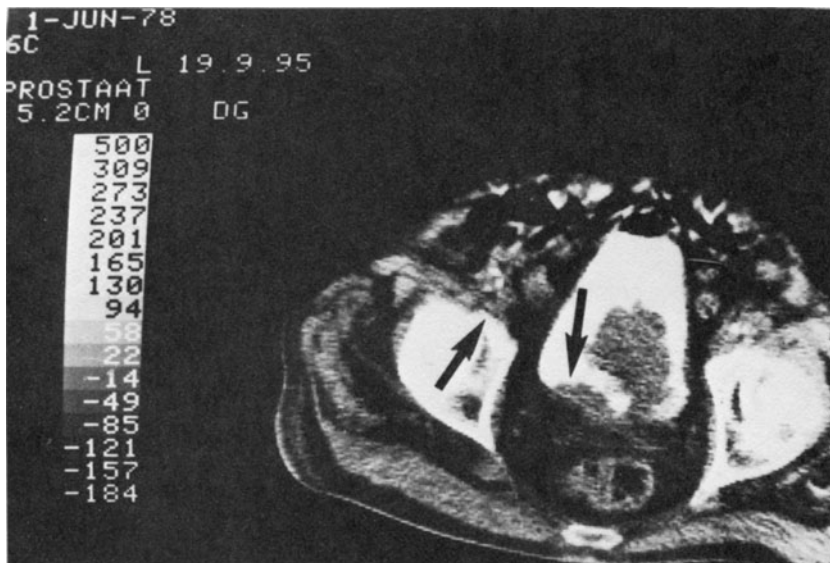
CT section of pelvis in a patient with advanced prostatic cancer demonstrates nodal obturator mass. Tumor invasion diagnosed by percutaneous fine needle biopsy.
